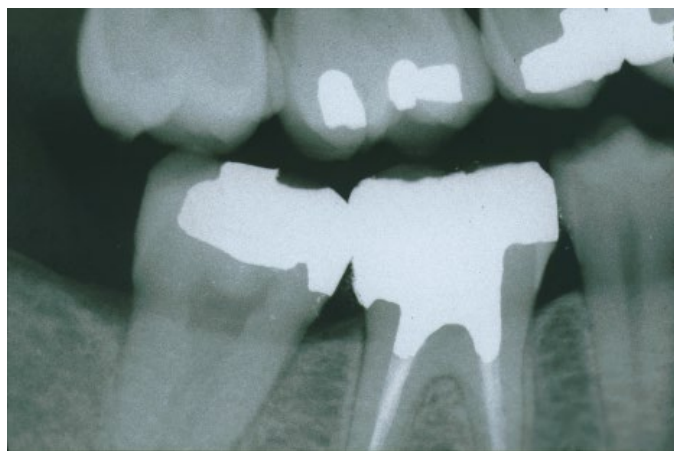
(B) Bitewing radiograph showing tooth #30 with amalgam core buildup completed. Note that the core material extends approximately 2 mm into the canal orifices for increased retention.
